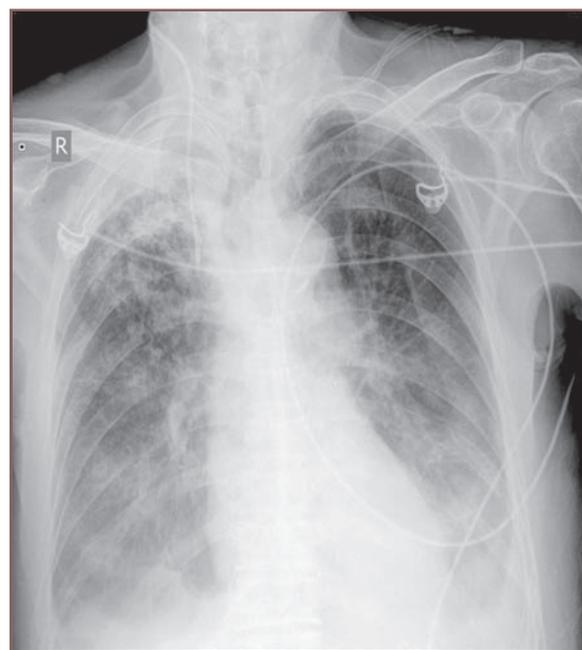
Chest radiograph of a patient with severe CRAB associated pneumonia and bacteremia
